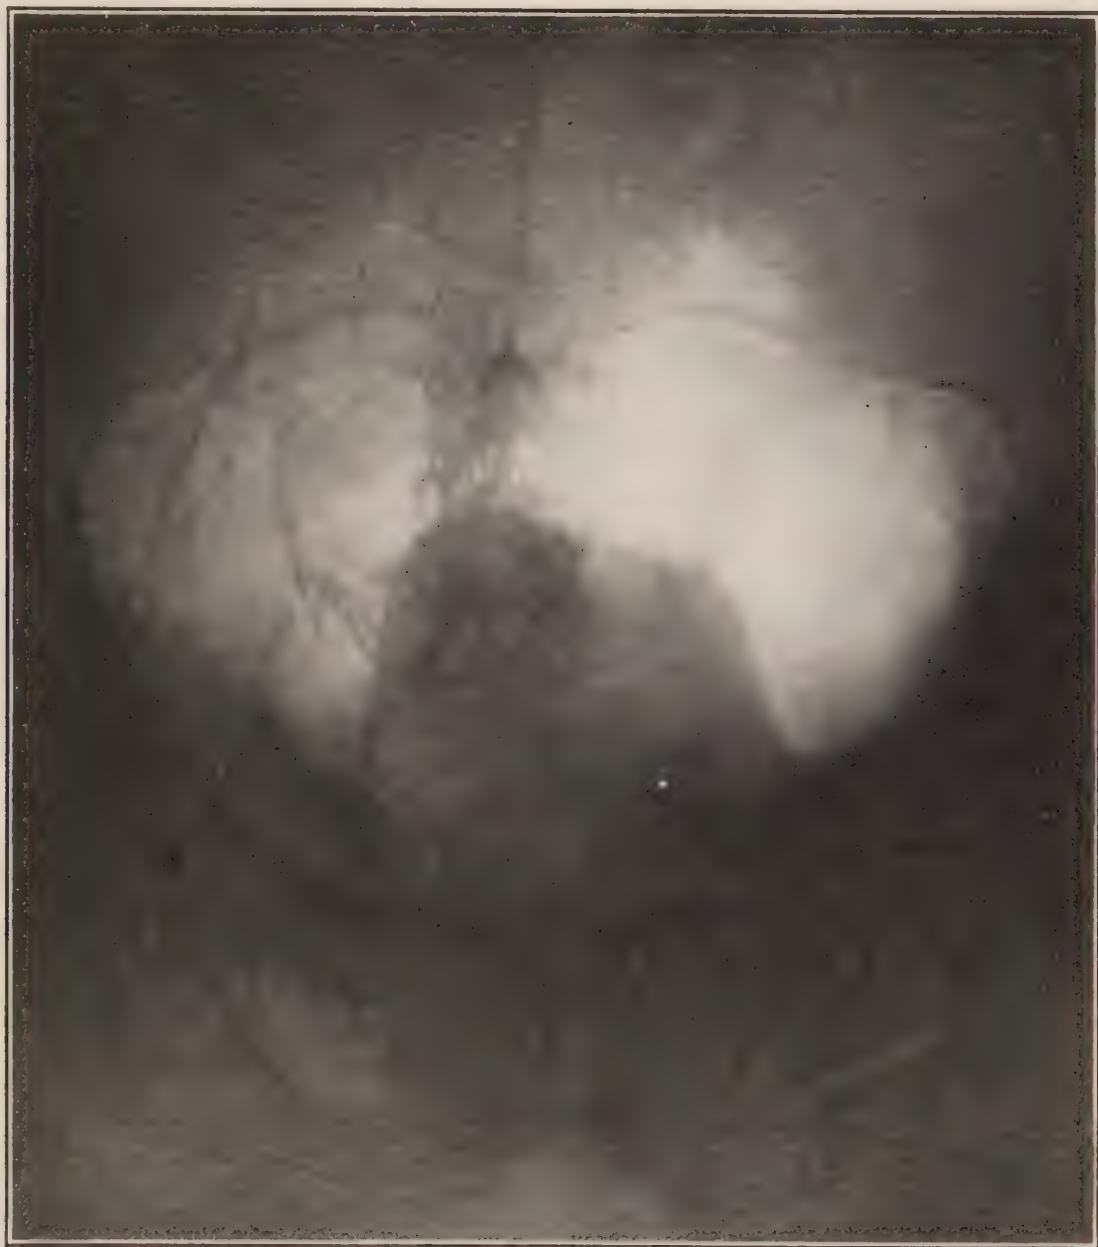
Enlarged prostate shown by radiography of bladder filled with air.
